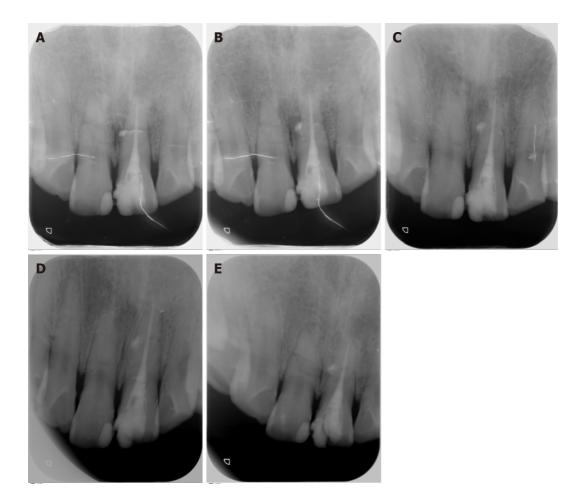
Periapical radiographs. A: At immediate post-obturation; B: 1-mo follow-up; C: 6-mo follow-up; D: 12-mo follow-up; E: 24-mo follow-up.
